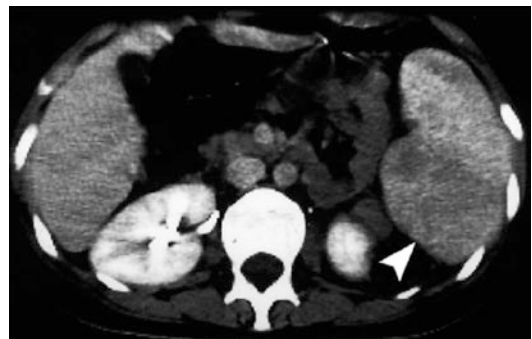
Five-year-old boy with sickle cell disease and left hypochondrium pain. Axial CE-CT showing heterogeneous enhancement of the spleen corresponding to splenic infarction (arrowhead)
